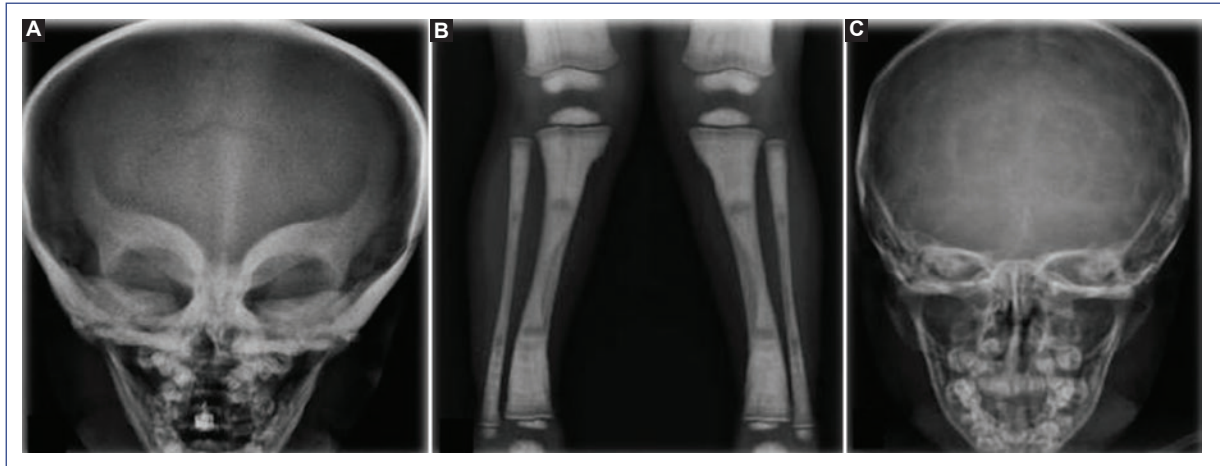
Osteopetrosis patient imaging studies. A. X-ray of the skull showing *mask* sign. Predominant generalized bone hyperdensity is observed at the base of the skull (before transplantation). B. X-ray of tibia and fibula with the *bone within a bone* sign. C. X-ray of the skull after transplantation with decreased bone hyperdensity.
